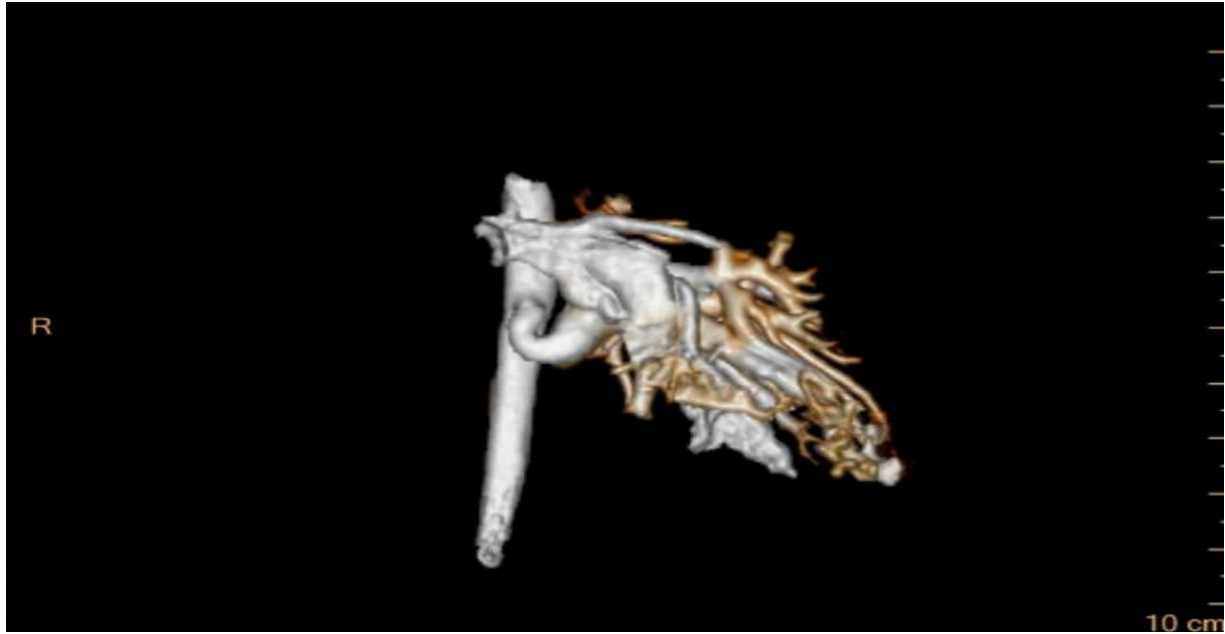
The large anomalous systemic artery from descending aorta coursing towards the left low lobe of the lung on 3D reconstruction of CTA
